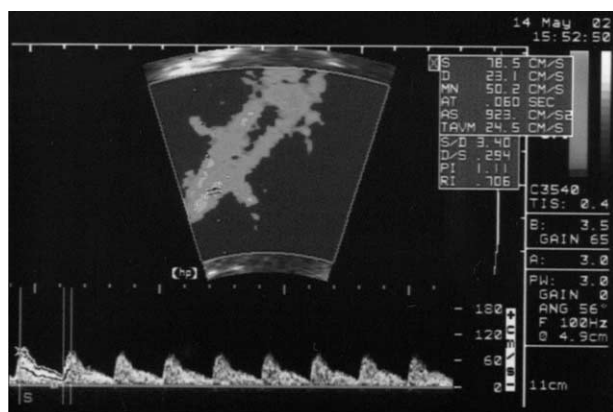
Doppler velocimetry in the aorta (infrarenal segment), showing the wall filter, insonation angle, site of insonation and measurement of peak systolic velocity (S), end-diastolic velocity (D) and resistance index (RI).
